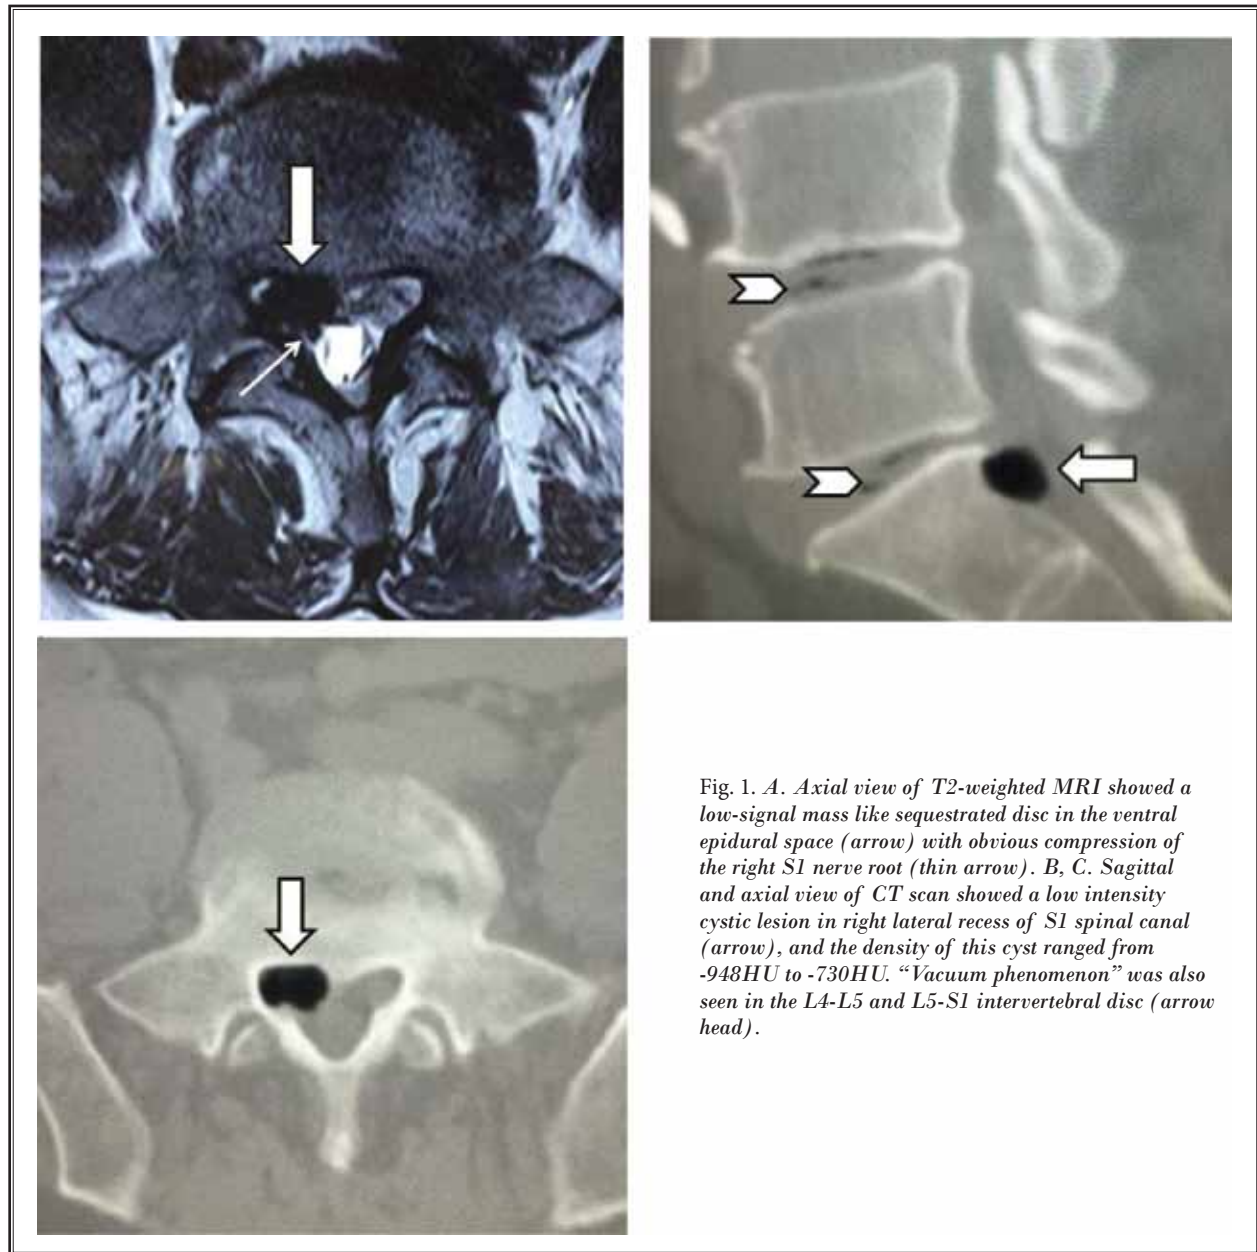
A. Axial view of T2-weighted MRI showed a low-signal mass like sequestered disc in the ventral epidural space (arrow) with obvious compression of the right S1 nerve root (thin arrow). B, C. Sagittal and axial view of CT scan showed a low intensity cystic lesion in right lateral recess of S1 spinal canal (arrow), and the density of this cyst ranged from -948HU to -730HU. “Vacuum phenomenon” was also seen in the L4-L5 and L5-S1 intervertebral disc (arrow head).
